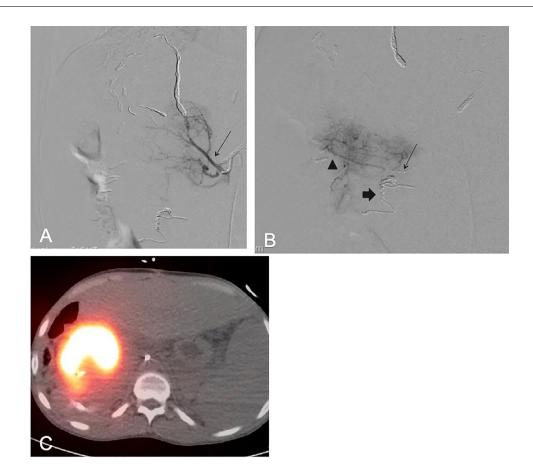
A 16-year-old male with fibrolamellar hepatocellular carcinoma undergoing catheter angiography for radioembolization (a) Right inferior phrenic digital subtraction arteriogram demonstrates consolidated tumoral supply after coil embolization of distal diaphragmatic and left inferior phrenic arterial branches. (b) Superior mesenteric artery tumor branch digital subtraction arteriogram through an antireflux catheter demonstrates arterial supply (triangle) and tumor blush. A jejunal and inferior pancreaticoduodenal branch were coiled (block arrow). (c) Postradioembolization axial SPECT-CT demonstrating high uptake in the tumor without any nontarget activity.
